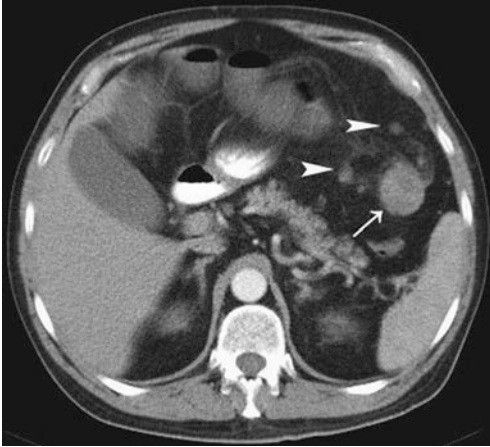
Enhanced CT of the abdomen shows a mass in the left colic flexure (*arrow*), infiltration of the pericolic fat, and small lymph nodes (*arrowheads*)
